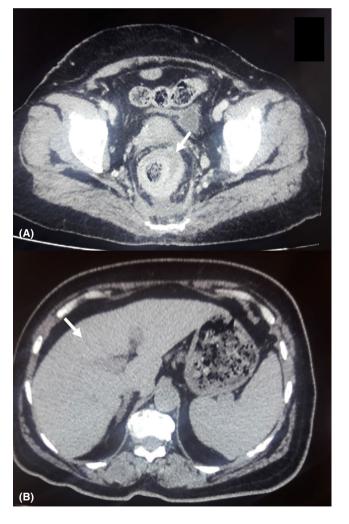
Computed tomography scan showing (A) a circumferential thickening of the medium and low rectum (arrow). (B) There were no hepatic metastases
